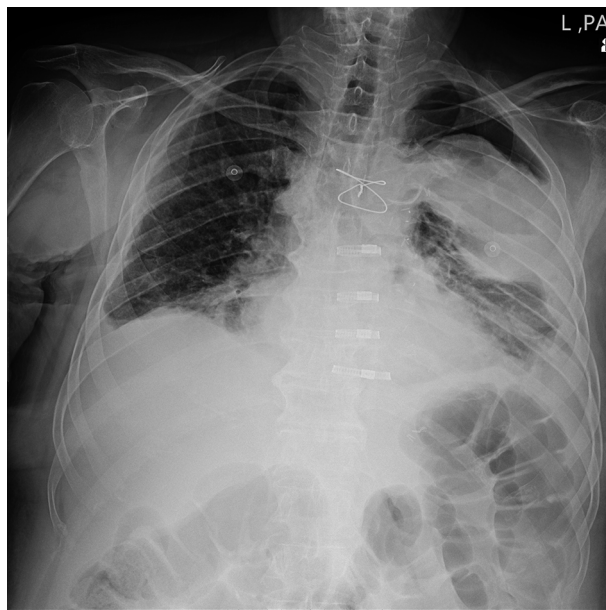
Chest X-Ray reveals left pneumothorax, bilateral pleural effusion and consolidation in the left upper lobe.
